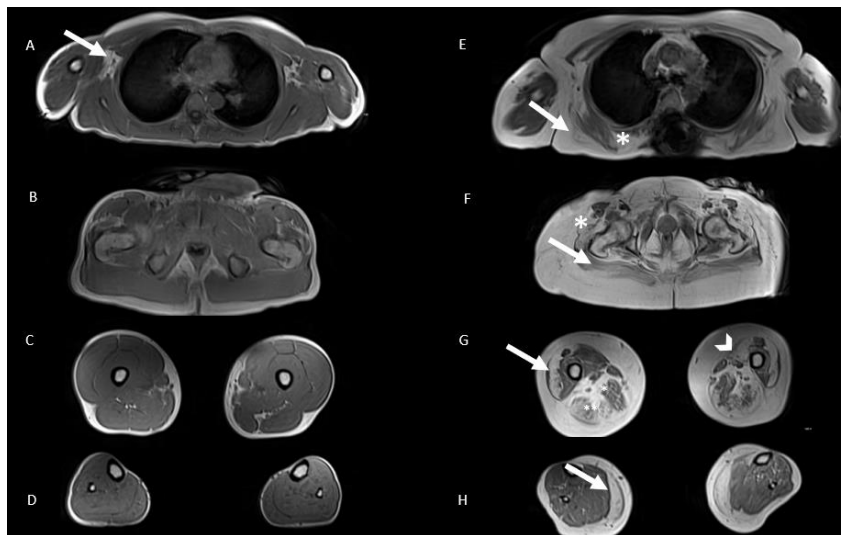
Muscle MRI in Multicore Myopathy (Family 12 -12.1, 12.2): Axial T1, Dixon 2 point in-phase images of patient 1 (son, left, A-D) and patient 2 (mother, right, E-H). A-D Normal MRI, who has repeated elevated CK >20,000 (N <250) with no fixed weakness. Patient 2. E. Mid chest: Severe fatty infiltration in latissimus dorsi and teres major (arrow). Severe fatty replacement of rhomboids major (*). F. Pelvis: Fatty replacement of gluteus maximus (arrow) and severe fatty replacement of tensor fascia lata (*). G. Mid-thigh: Moderate fatty infiltration in vastus medialis (left, chevron) and lateralis (bilaterally, arrow). Moderate atrophy and fat infiltration of the adductor magnus bilaterally (*). Severe right and moderate severe left fat infiltration of the semitendinosus and biceps femora (). I. Mid-calf: Progressive severe fatty atrophy of the medial head of the gastrocnemius (arrow).
